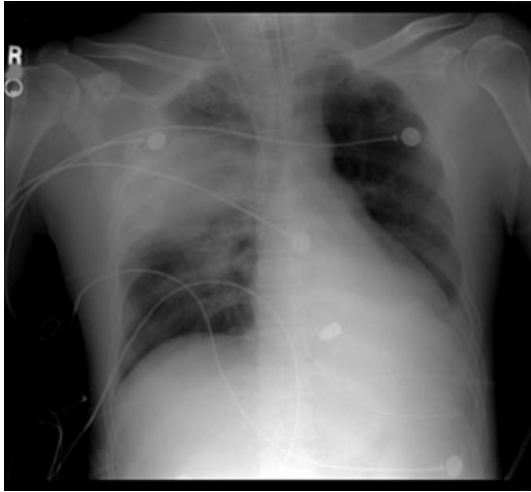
Anterior–posterior chest radiograph from July 2007 admission shows marked right upper lobe consolidation and persistence of the radio-dense projectile in the anterior mediastinum.
